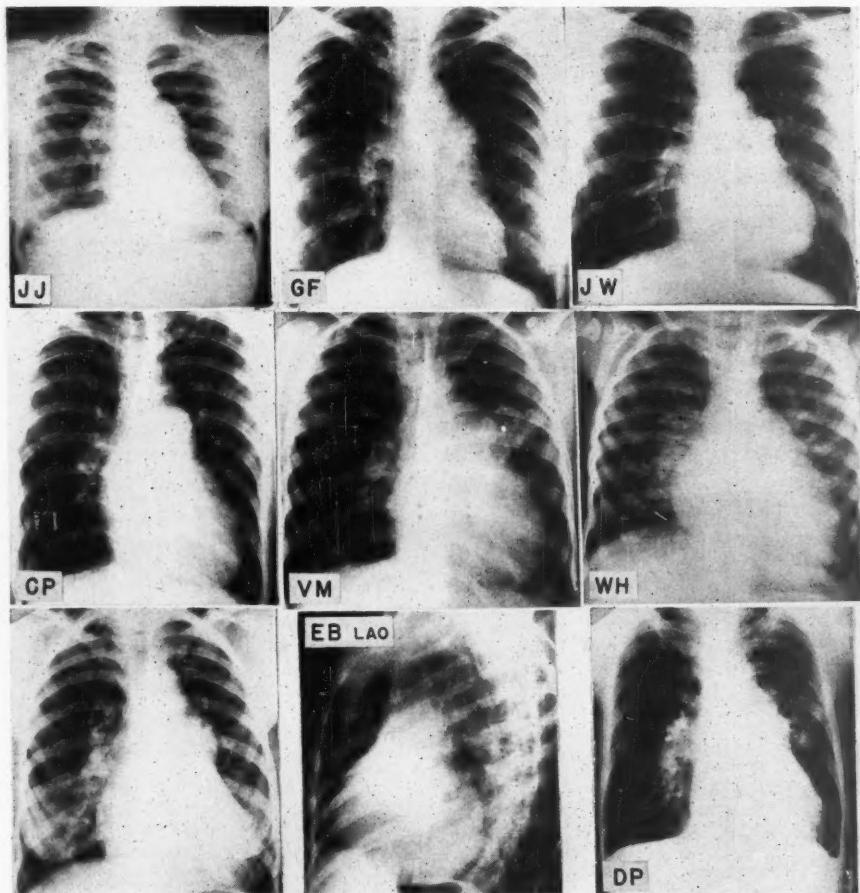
Anteroposterior roentgenograms of chests showing enlargement of pulmonary arteries. Left anterior oblique view of patient E. B. indicates moderate degree of left ventricular enlargement.
